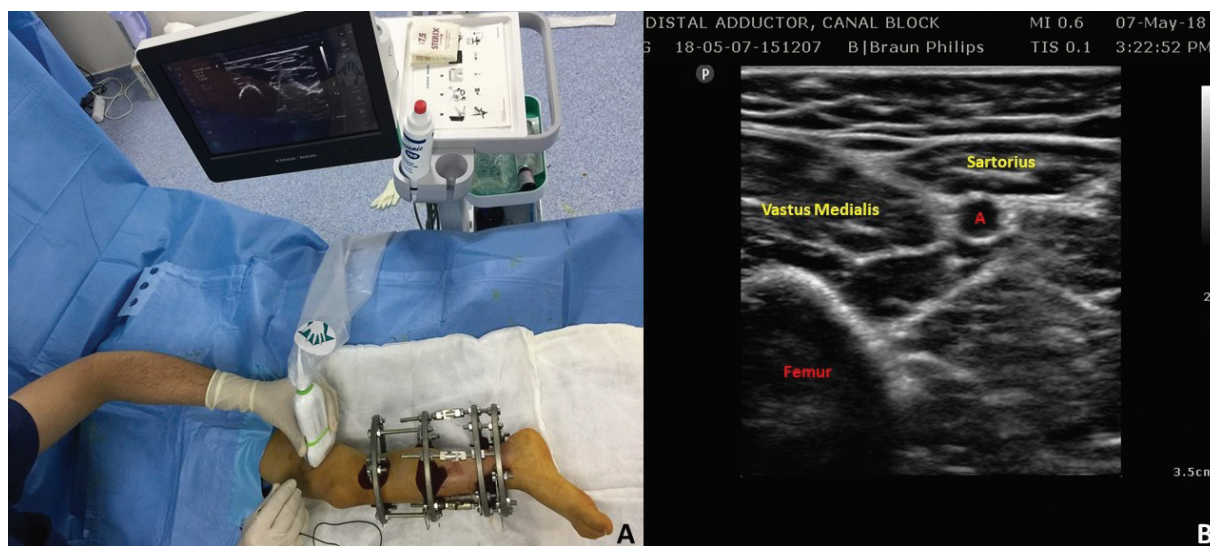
A. Ultrasound and Patient set up for Distal Adductor Canal Block. B- Sonographic Anatomy of Distal Adductor Canal. A, Superficial femoral artery.
